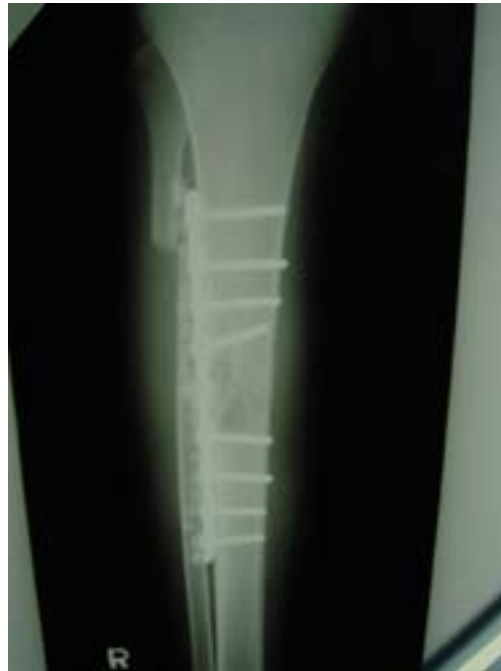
Plain radiograph showing plate at the lateral border of the tibia with antibiotic beads
